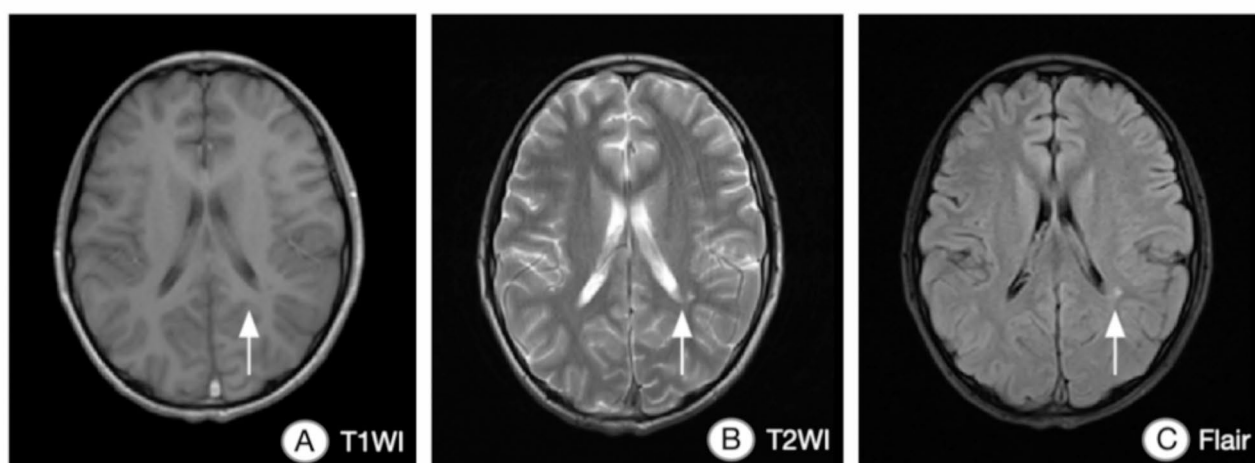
Non-contrast MRI during the patient's initial admission demonstrates patchy prolonged T1/T2 signals in the white matter of the left posterior horn of the lateral ventricle (A, B), with corresponding FLAIR hyperintensity (C)
